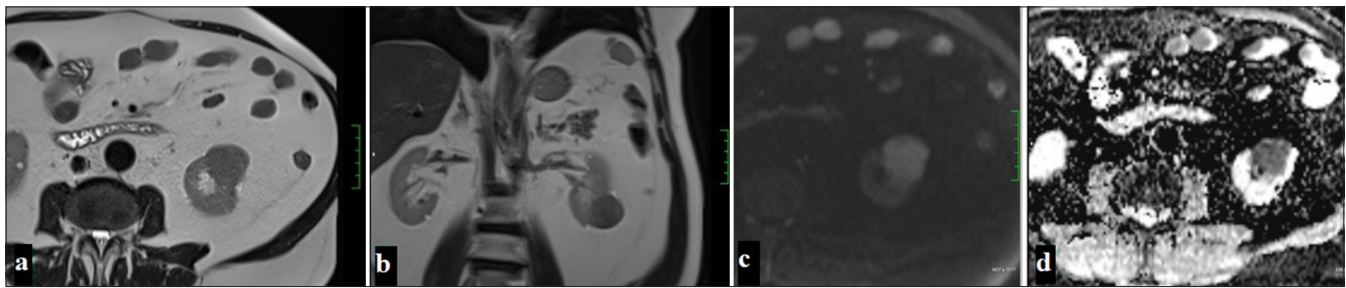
A 54-year-old man with a lesion observed as hypointense in T2-weighted imaging on axial (a) and coronal (b) planes on MRI, hyperintense on DWI (c), and showing diffusion restriction suggestive of malignancy on ADC (d) (Papillary renal cell carcinoma).
